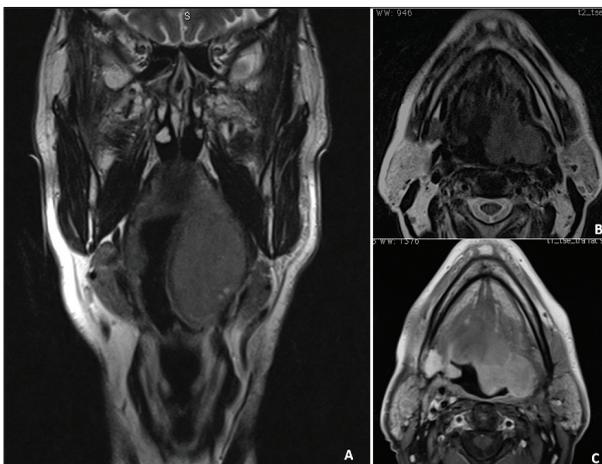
(a-b) Waldeyer's ring lesion. MRI T2w. Nodular capsulated solid lesion in the left parapharyngeal space with reduction of the pharyngeal airspace. (c) After i.v administration the lesion show midly inhomogeneous enhancement.
